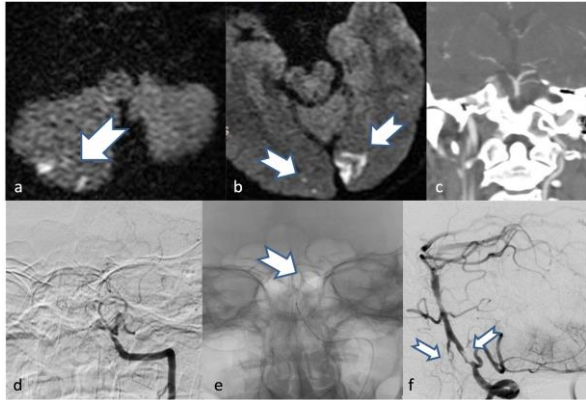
DWI at admission of Case 7 arrows showing the acute ischemic lesions, c. Coronal plane CTA showing intact distal flow, d. DSA showing proximal basilar and distal left vertebral artery occlusion, e. DSA showing stent retriever (arrow) at left PCA, f. Dissection at bilateral vertebral arteries (arrows).
